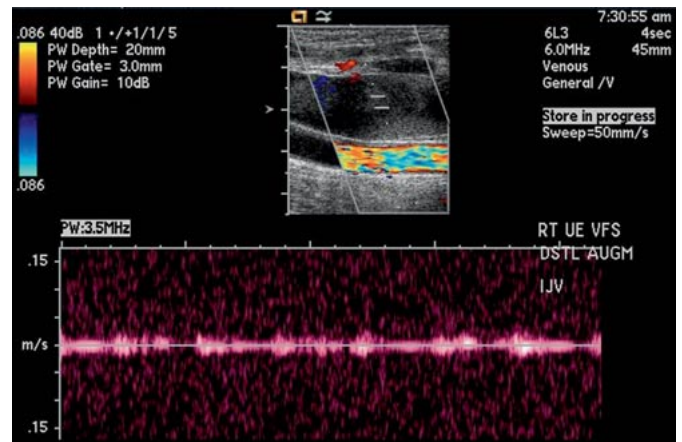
Color Doppler assists the sonographer to identify these two distinct vessels.
